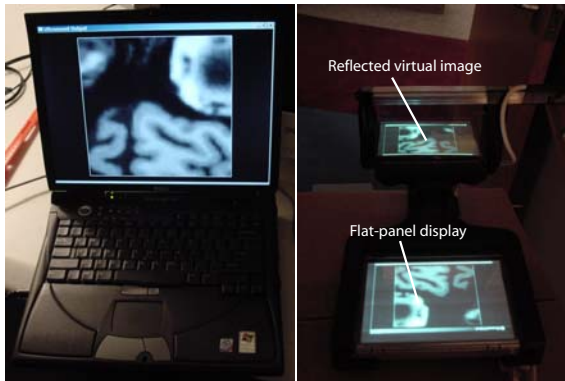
Virtual ultrasound slice through an MRI of the brain, displayed on laptop computer (left) and Sonic Flashlight (right)
